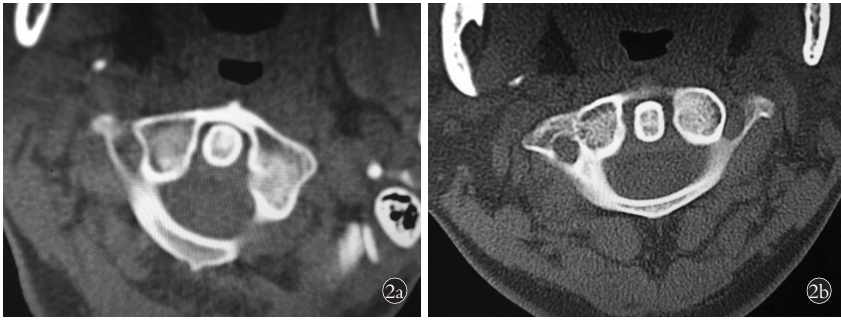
女性患者,41 岁,外伤致寰枢椎关节半脱位 2a. 治疗前 CT 示寰枢椎间隙不对称,右侧约 2 mm,左侧约 3 mm 2b. 经过 1 个疗程的牵引治疗后复查 CT 示寰枢椎间隙左右对称,疼痛缓解,活动自如
